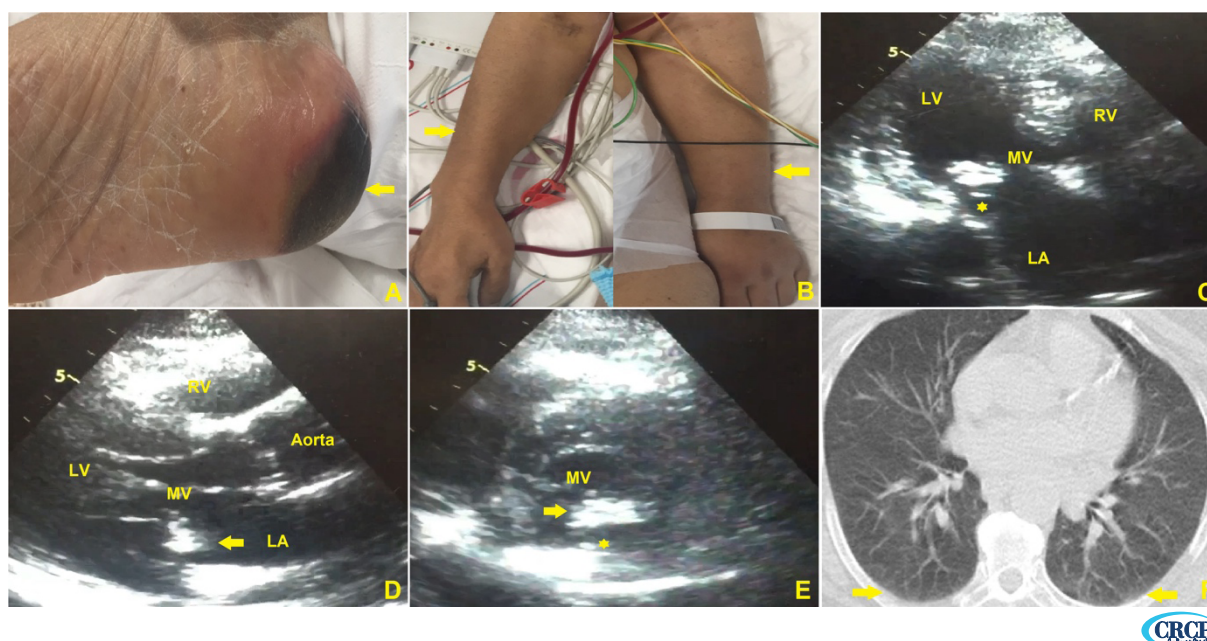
A) An ecchymotic lesion suggesting peripheral embolism was noted on the sole of the right foot (arrow); B) The diameter of the left arm compared to the right arm was increased, suggesting a venous obstruction (arrows); C,D,E) Transthoracic echocardiography images outlining a hyperechogenic mass surrounded by hypoechoic vegetation (arrows) and partial chorda rupture (*) on the parasternal long-axis, parasternal short-axis, and apical 4-chamber views; F) Computed tomography image demonstrating mild ground glass infiltration (arrows) on the basal segments of the chest
